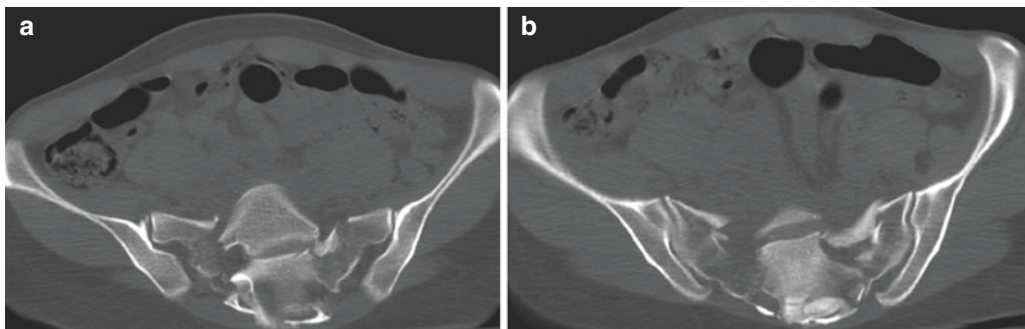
(a–e) Precipitated patient. “Vertical shear” (VS) fracture; condition of high instability. (a, b) CT axial view shows bilateral fractures of the sacrum along the course of the foramina, with diastasis of the sacroiliac joint (double vertical force component). CT MPR sagittal
